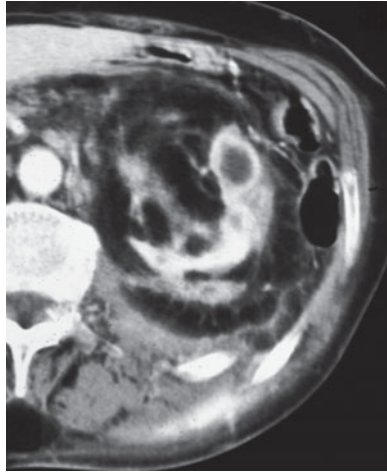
Contrast-enhanced CT. Replacement lipomatosis. The image shows parenchymal atrophy with an increase in renal sinus and perirenal fat and associated stranding. Cysts at the anterior renal lip are also visible
